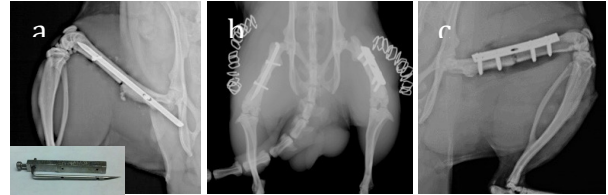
a) Lateral X-ray of IM nail (right femur). b) Anterior-Posterior xray of both femurs. c) Lateral X-ray of plate (left femur).
